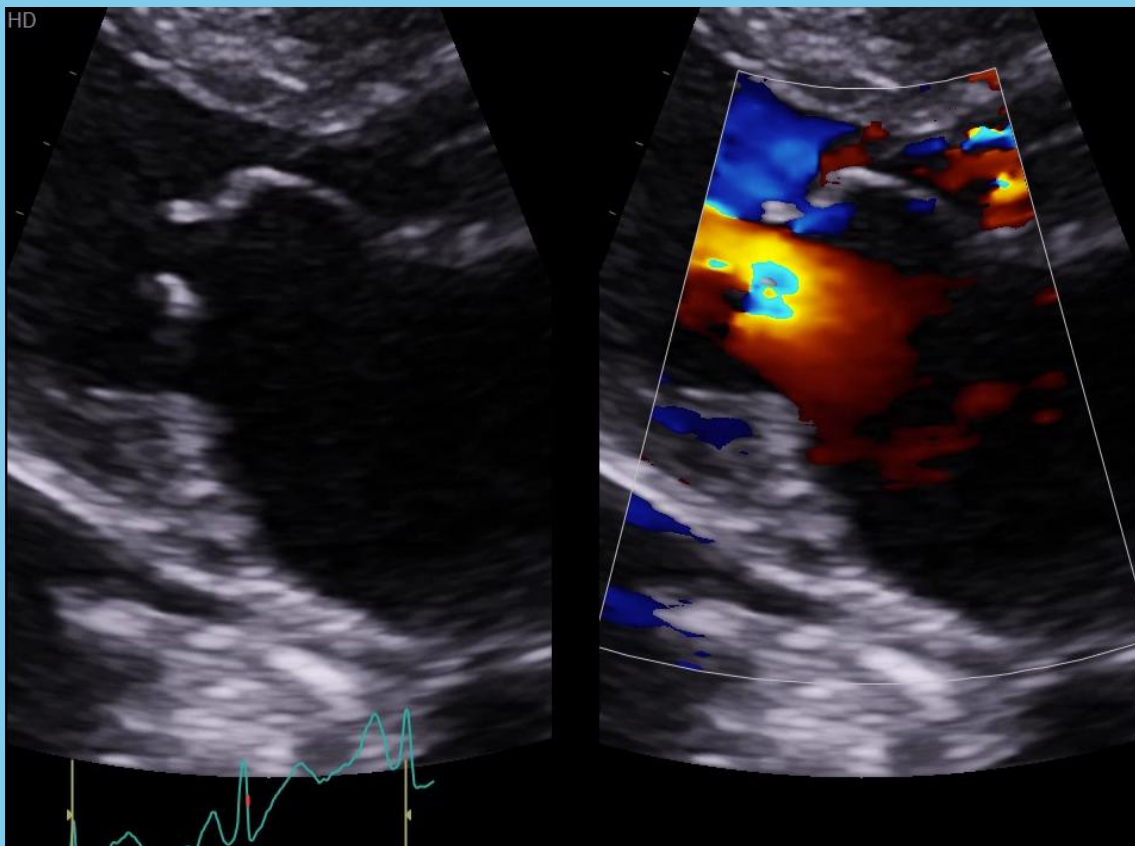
Echocardiography reveals dilated LA and rheumatic MV
